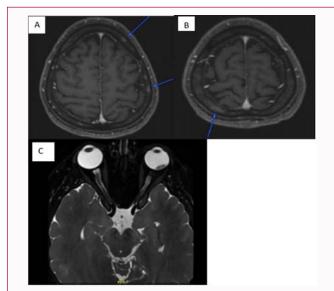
A&B) Multiple bilateral parietal and left frontal calvarial enhancing lesions likely metastasis. C) Left ocular enhancing lesion corresponding to the previously seen in PET-CT (Ocular metastasis).
